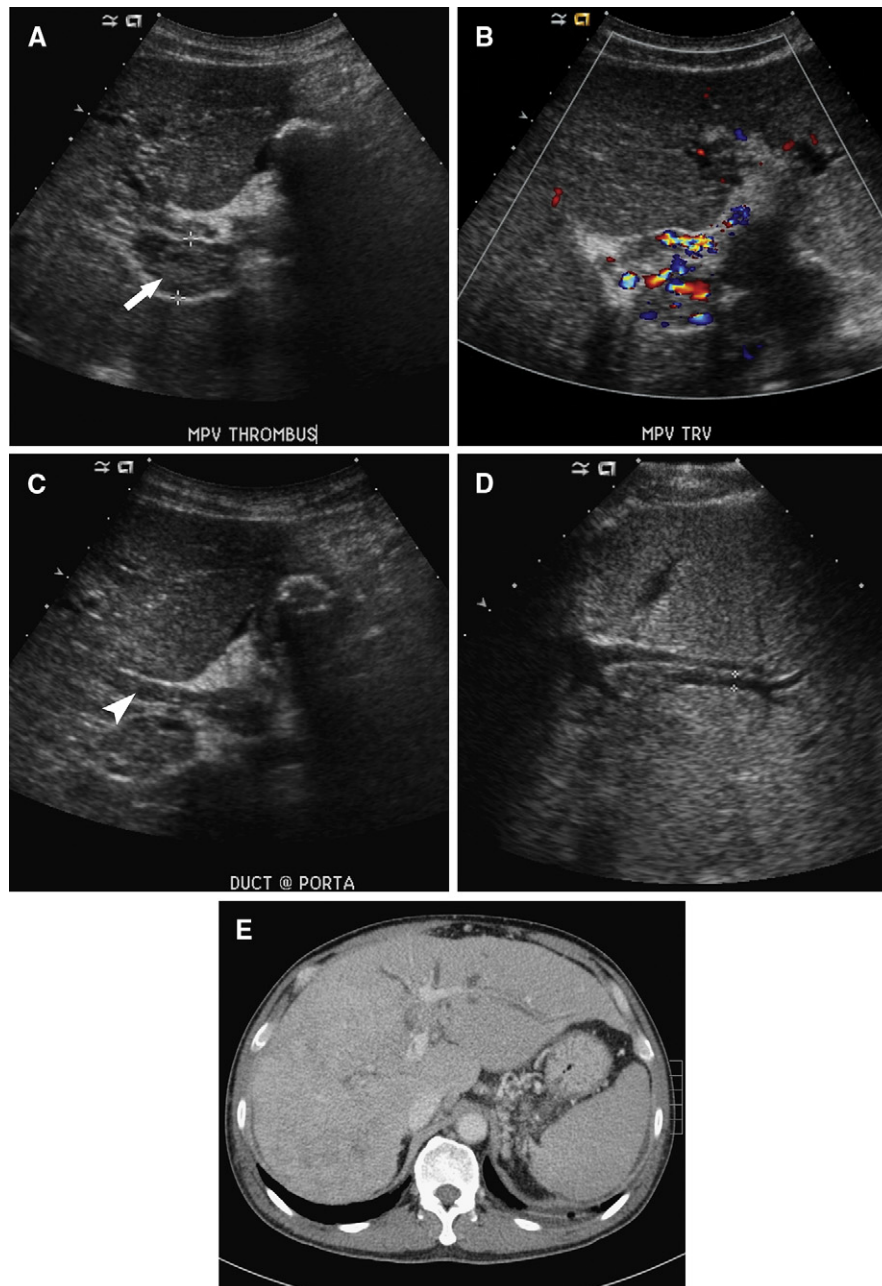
Additional findings on ultrasound (US) consistent with hepatocellular carcinoma (HCC). (A, B) Tumoural thrombus is located within the main portal vein (arrow). Colour Doppler US, demonstrating flow within the thrombus, indicating tumoural thrombus rather than bland thrombus. (C) Echogenic material is identified within the common bile duct (arrowhead), consistent with tumoural invasion. (D) Transverse transabdominal US, showing intrahepatic biliary duct dilatation. (E) The contrast-enhanced transaxial computed tomography, demonstrating a hepatic mass and exhibiting mass effect, and compressing on the adjacent biliary ducts and resulting in intrahepatic biliary duct dilatation. This figure is available in colour online at <http://www.carjonline.org/>.
